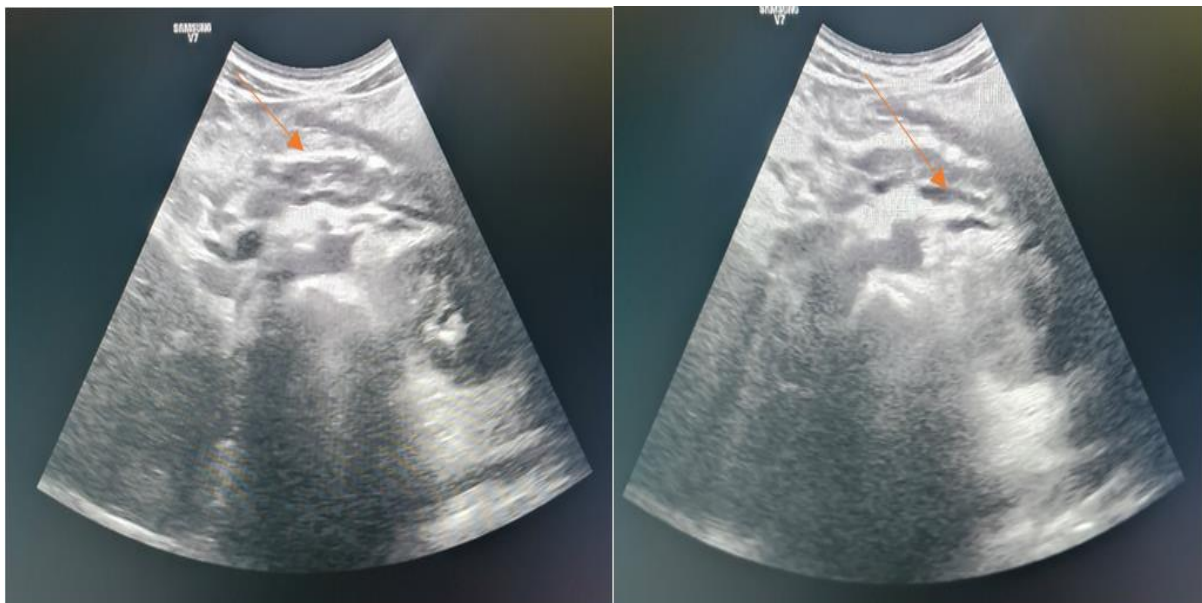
Follow-up Ultrasound of Abdomen: Arrow 1 Heteroechoic Echotexture of Pancreas with Mild Pancreatic Atrophy. Arrow 2 – no Significant Pancreatic/Peri-Pancreatic Collection. Echogenic Contents Seen within the Splenic Vein, Suggestive of Thrombosis
